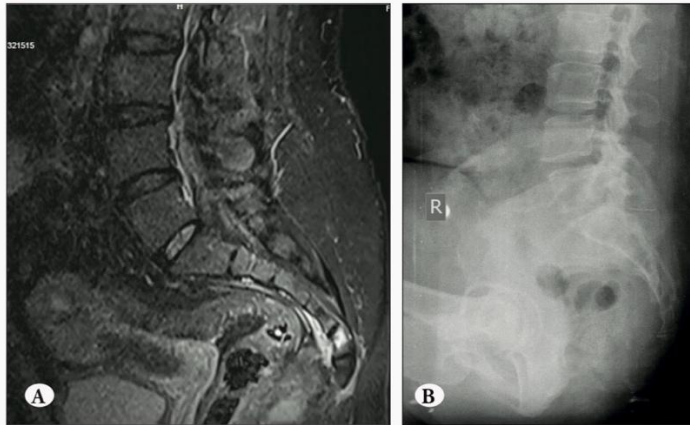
A) Bone marrow edema in the sacrococcygeal region. B) Suspected fracture line on plain radiography of the coccyx.
